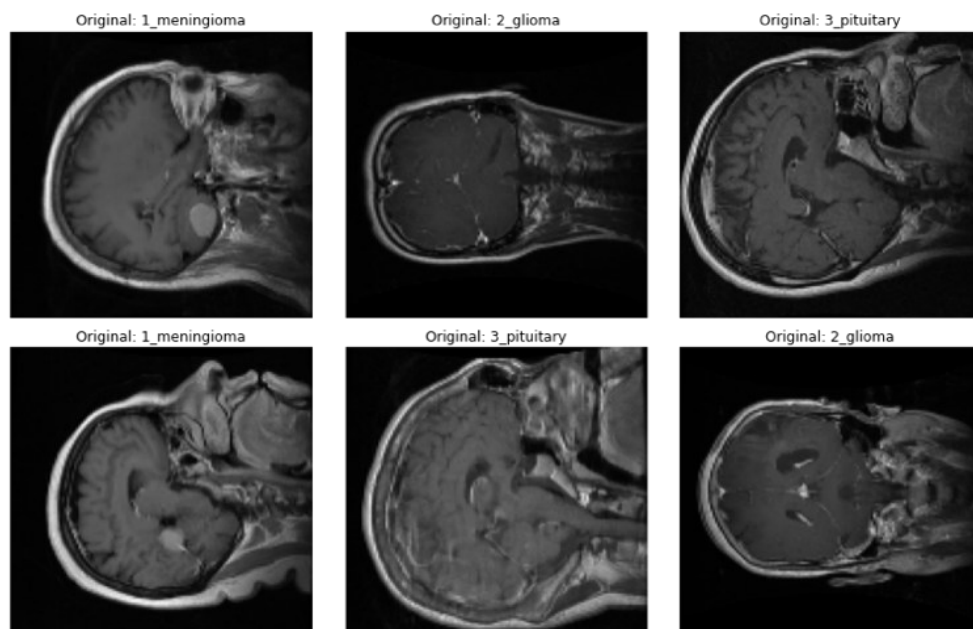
Sample Images from the T1-CE Brain Tumor MRI Dataset
